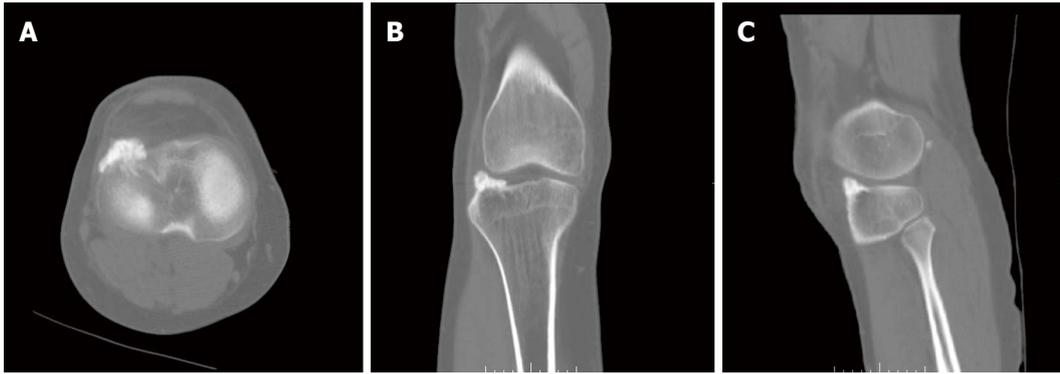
Initial computed tomography images of the right knee in the axial (A), coronal (B), and sagittal (C) planes.
